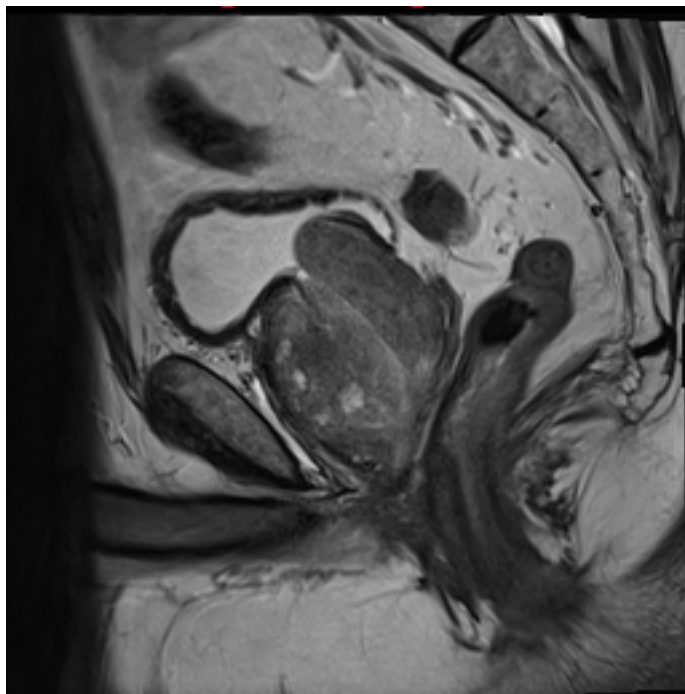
Sagittal and axial MR images of the prostate 5 years after PAE, demonstrating enlarged heterogenous gland consistent with BPH. Total gland volume measured 119 cc, with transitional zone volume of 94 cc.
